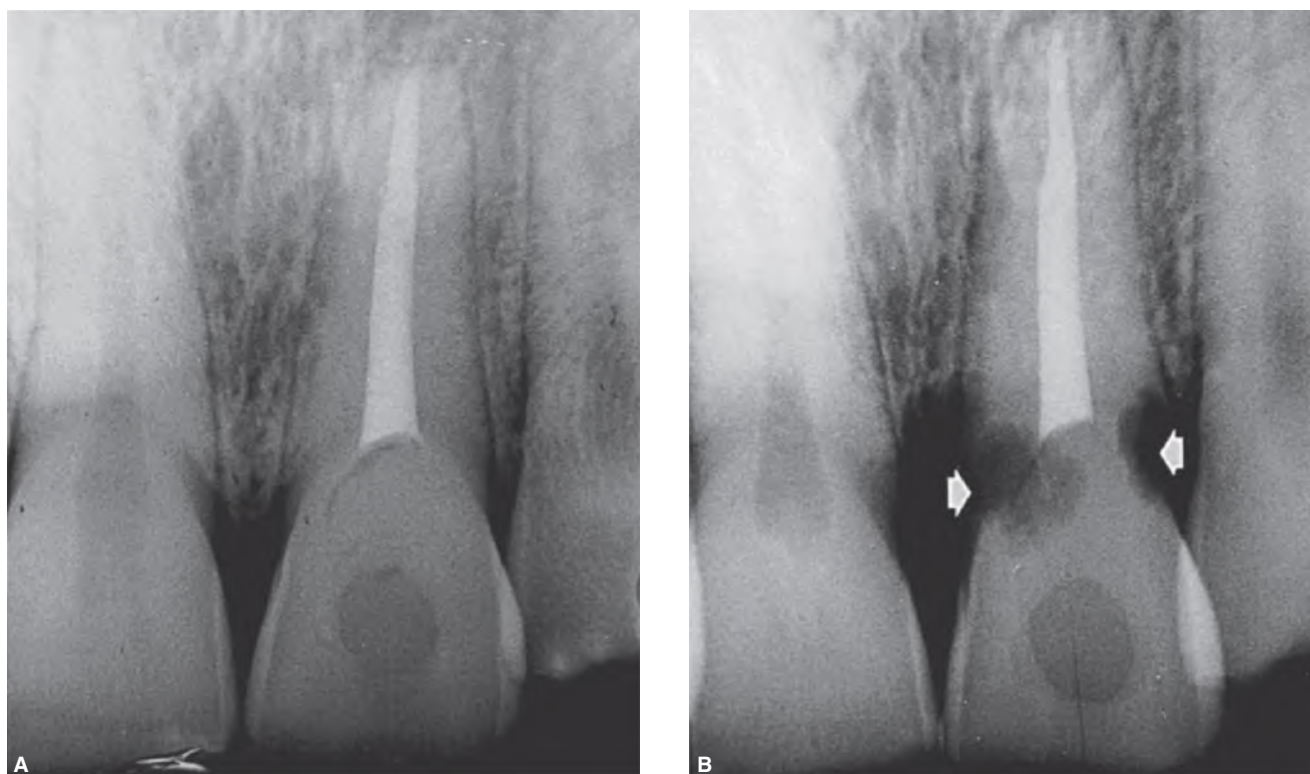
External root resorption following thermocatalytic bleaching. A. Nine-year recall radiograph of a maxillary central incisor devitalized by trauma and treated endodontically shortly thereafter. B. Radiograph taken 2 years following bleaching showing evidence of root resorption (arrows). Highly concentrated H_2O_2 and heat were used as part of the treatment. (Reproduced with permission from Harrington GW, Natkin E. *J Endod.* 1979;5:344-348.⁴⁴)
